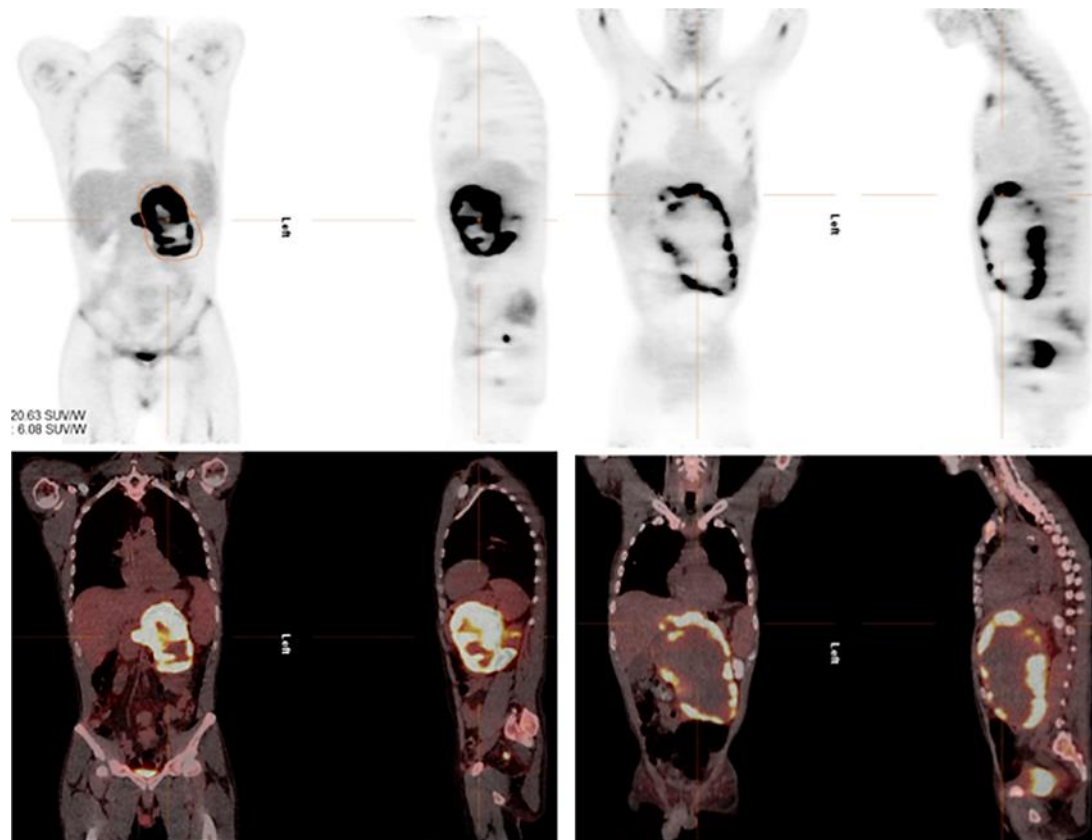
Baseline FDG-PET/CT (left) demonstrating an FDG avid tumor is compared to interim FDG-PET/CT after 5 weeks of treatment with RRx-001 (right). The treatment effect is indicated by extensive central tumor necrosis with a thin halo of the apparently viable tumor.
